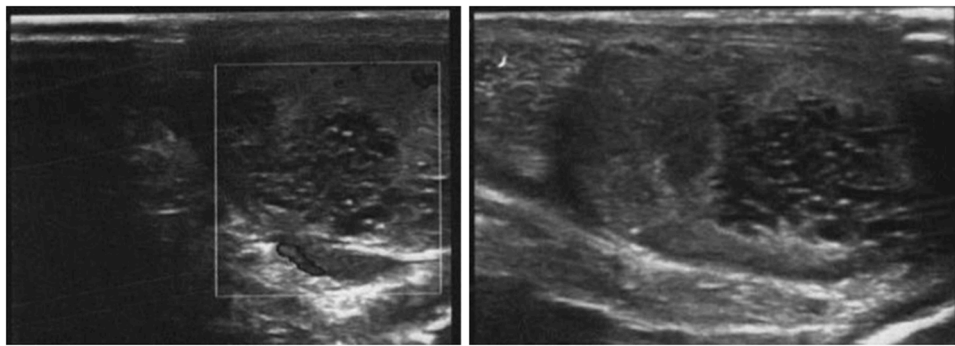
Cystic mass in the ultrasound examination.
